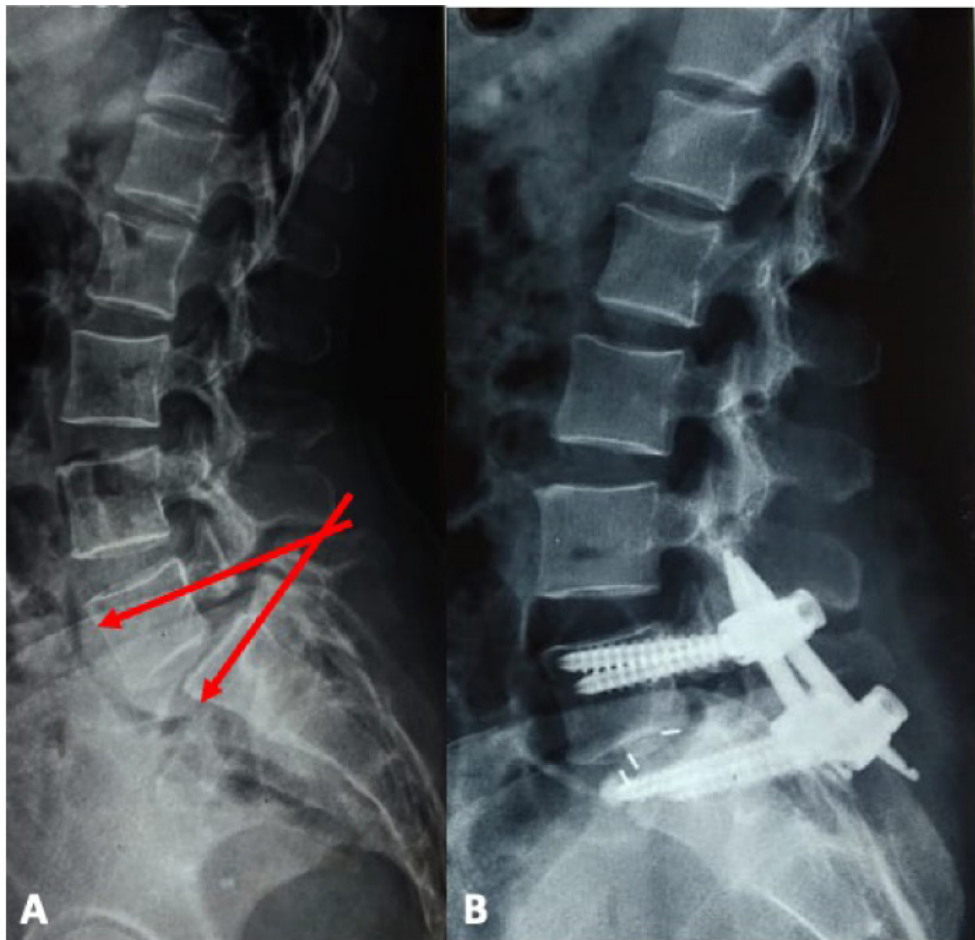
(A) Lateral preoperative X-ray showing L5 S1 isthmus spondylolisthesis with red arrows showing the trajectories L5, S1 screw with the extension tabs. (B) Post-operative lateral X-ray showing L5/S1 minimally invasive TLIF (MISS-TLIF). The possible screw impingement was avoided by selecting a slightly lower entry point for S1 screw bilaterally.
